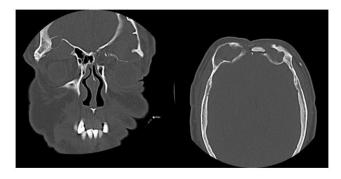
Coronal and axial pre-operative CT image.
